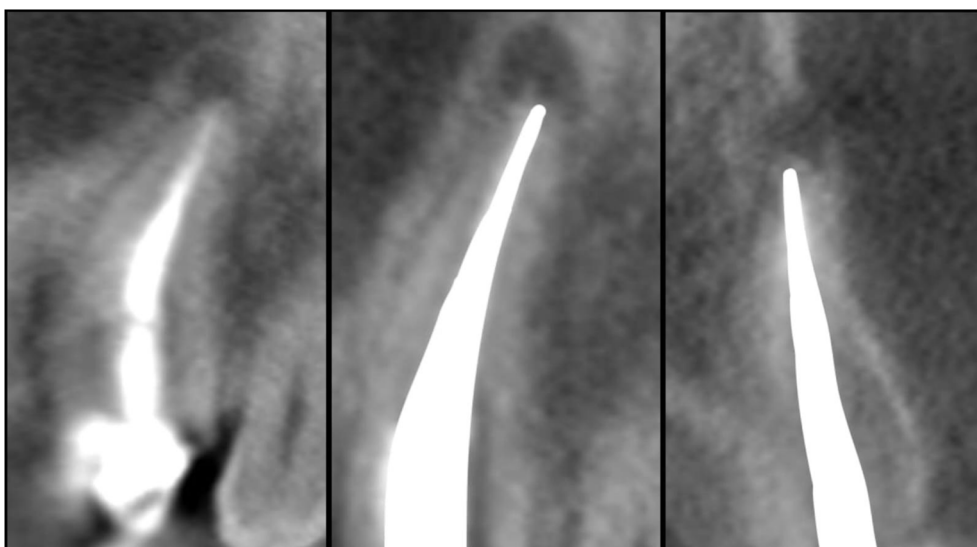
An example of a tooth with a metal intra-radicular post with a periapical radiolucent lesion (coronal and sagittal)
